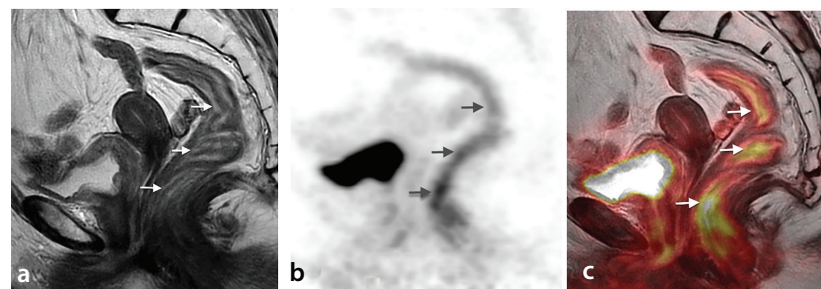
Radiation-induced proctitis in a patient with cervical cancer. The sagittal T2-weighted magnetic resonance image (MRI) (a) shows rectal wall thickening and submucosal edema (arrows) in a patient who underwent radiation therapy. The sagittal positron emission tomography (PET) (b) and sagittal fused PET/MRI (c) demonstrate increased uptake consistent with post-radiation inflammation.
